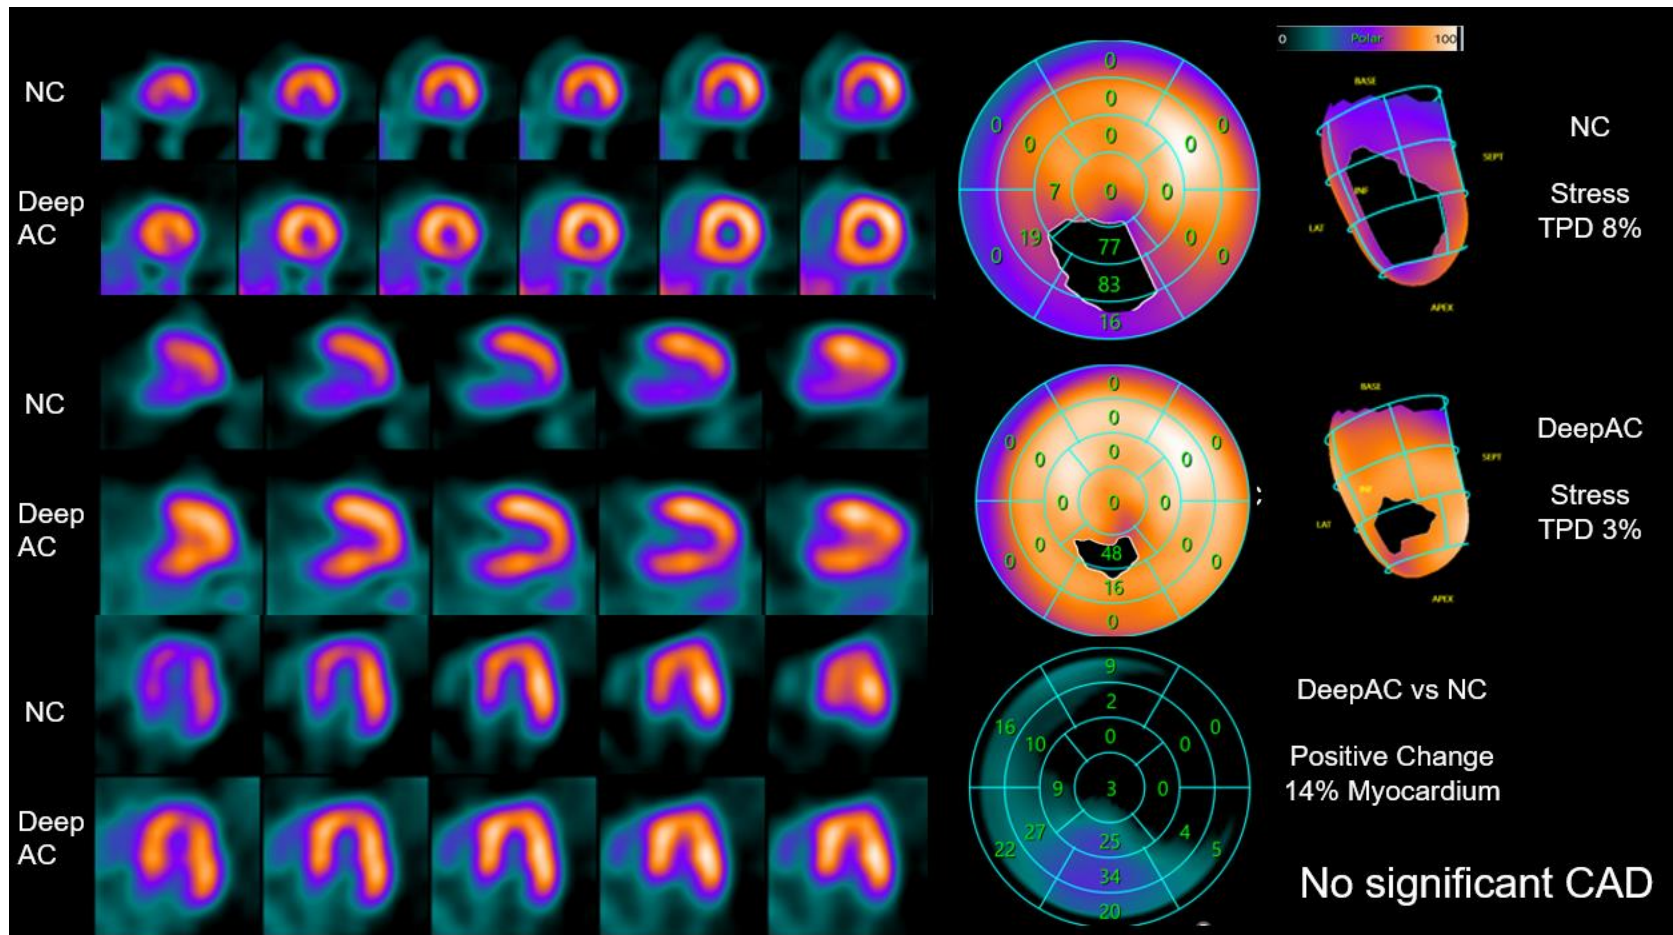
Case example with no significant coronary artery disease (CAD). A 61-year-old female patient with body mass index of 30 kg/m^2 . Non attenuation correction (NC) stress total perfusion deficit (TPD) was abnormal at 8%. One reader interpreted the SPECT NC scan as definitely abnormal and the other two as definitely normal. DeepAC shows only minimal abnormality in the inferior apical segment (3% stress TPD). Invasive coronary angiography demonstrated no obstructive coronary artery disease (maximum stenosis 34% in the left anterior descending artery).
